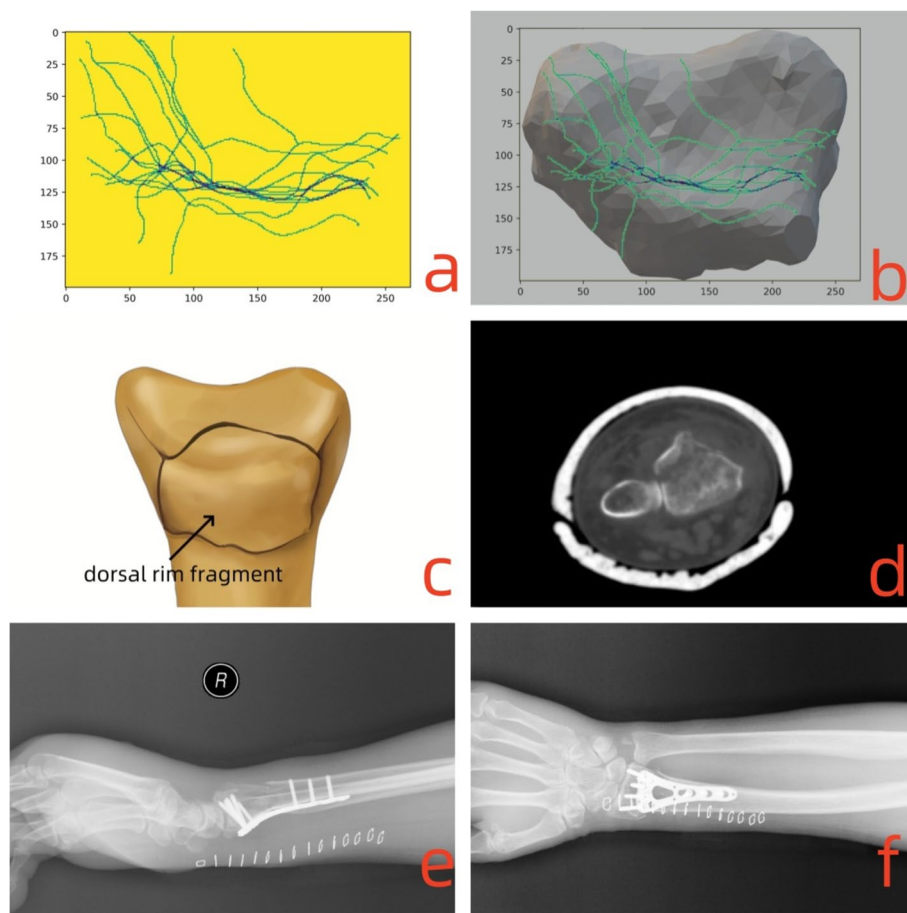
For type 1.2 DRFs, the coronal fracture line is closed to the dorsal side and forms the dorsal fragment. The morphological characteristics and the clinical treatment were shown as follows: a)-b) the fracture lines clustered and covered on the intra-articular surface; c) the model for type 1.2 DRFs; d) the CT scan for the fracture lines at the articular surface; e)-f) postoperative posteroanterior and lateral X-ray images
